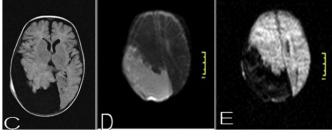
Arachnoid Cyst. (a) T1-weighted axial image showing well-defined hypointense cystic lesion in right parieto-occipital region. (b) T2-weighted axial image demonstrates the lesion to be brightly hyperintense. (c) Post-gadolinium axial image showing no enhancement of the lesion. (d) ADC map showing high signal (e)
